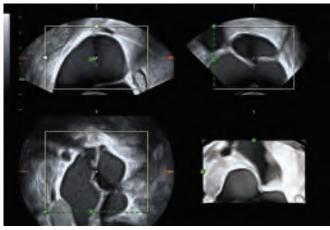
Three-dimensional ultrasound of a pelvic inflammatory conglomerate. By conventional B-mode ultrasound hydrosalpinx can be mistaken for a multilocular cyst, but when 3D is applied the true, spatial position and shape of hydrosalpinx is clearly visible
